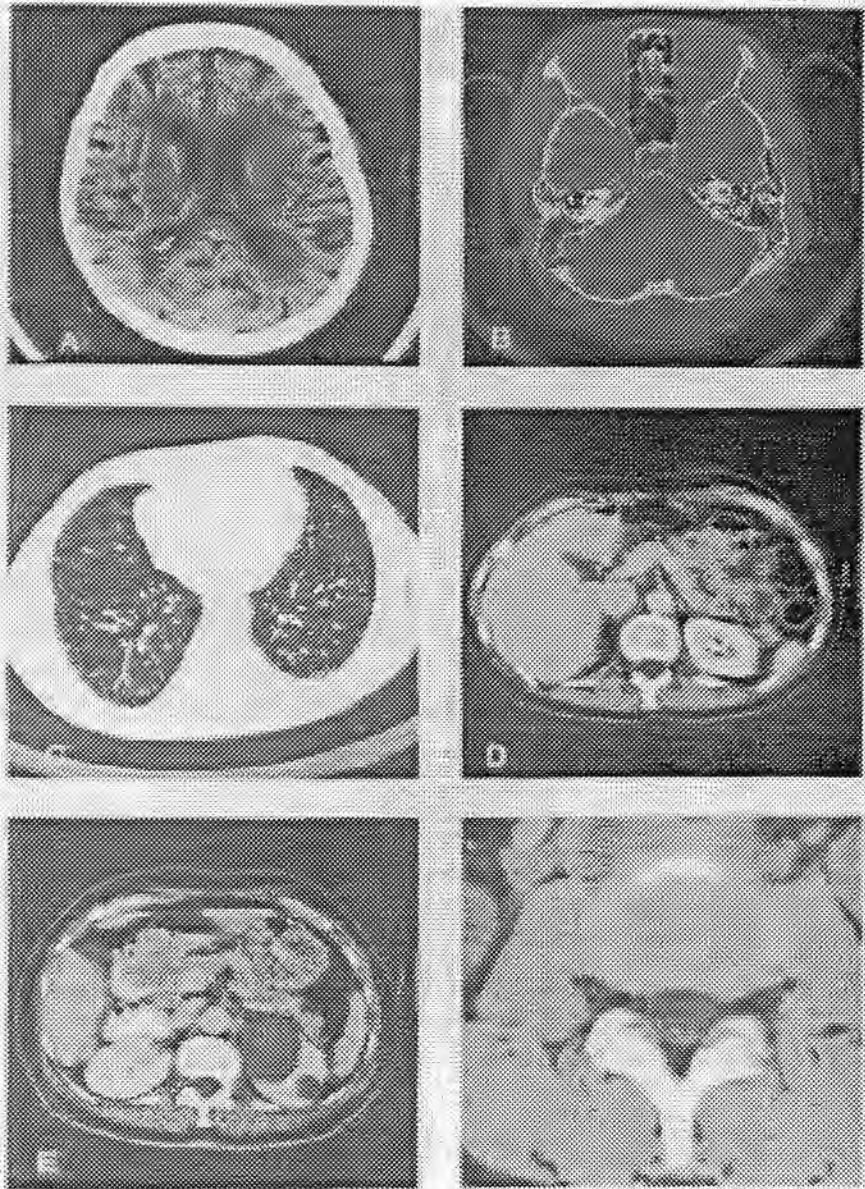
Examples of CT images of the head, chest, abdomen, and spine produced by a modern CT scanner (Seeram 1994).
